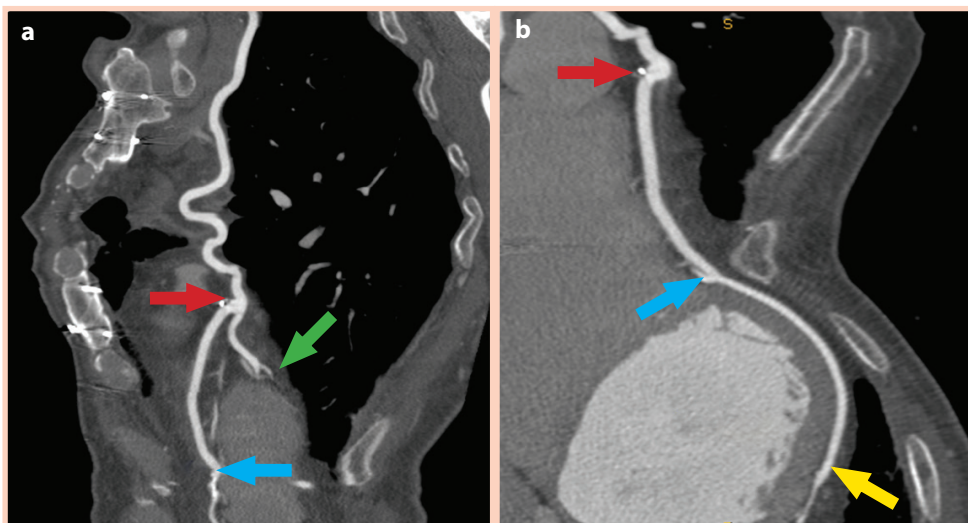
CT image of Y anastomosis of LIMA on proximal LAD/Dg1 (a, b, red arrow), LIMA on Dg1 (a, green arrow), LRA with a jump to distal LAD (a, b, blue arrow) and LRA to CX (b, yellow arrow).
